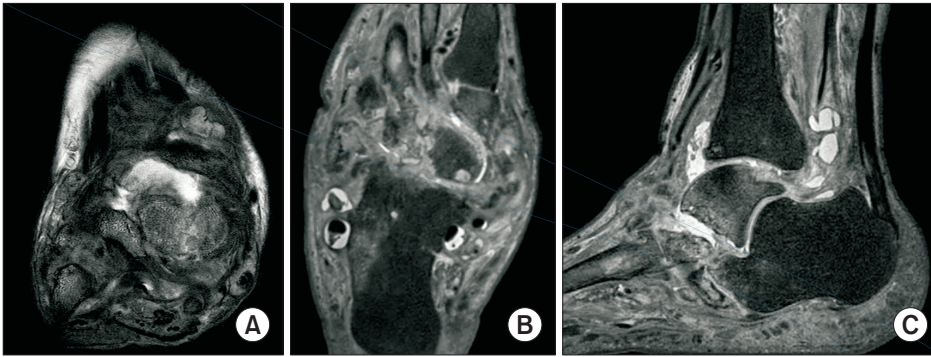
Preoperative T2-weighted magnetic resonance imaging showing bone marrow edema and joint destruction. Fluid collection and edematous change were also observed.
